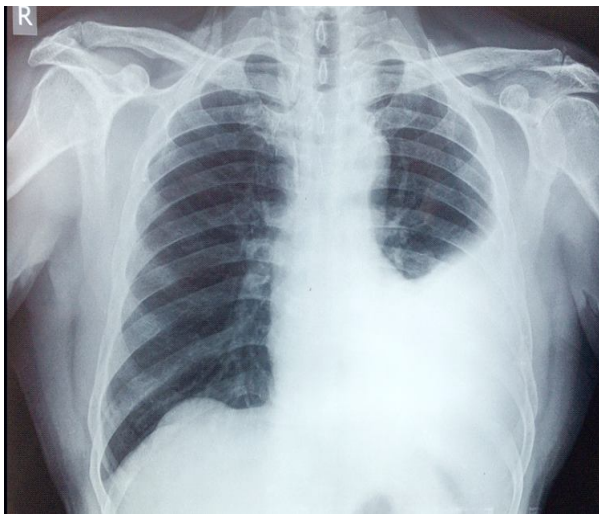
Chest x-ray revealed left sided pleural effusion.
